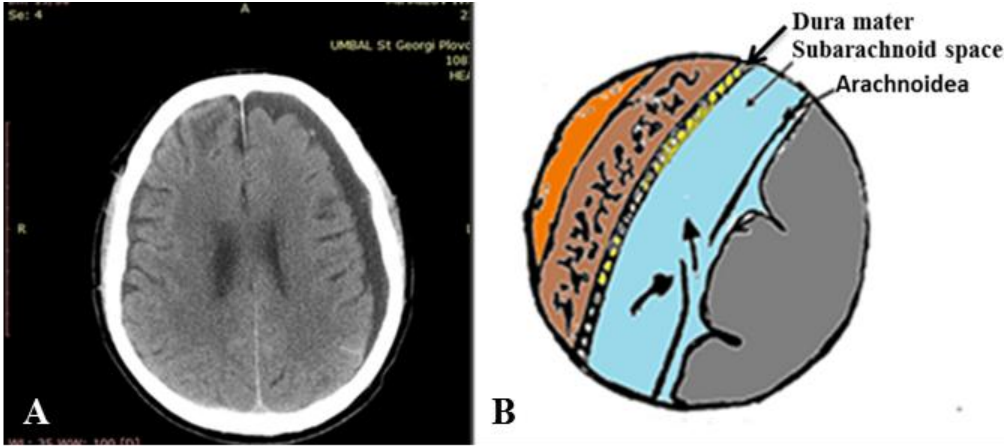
A/ CT image of subdural hydroma; B/ ball-valve mechanism
